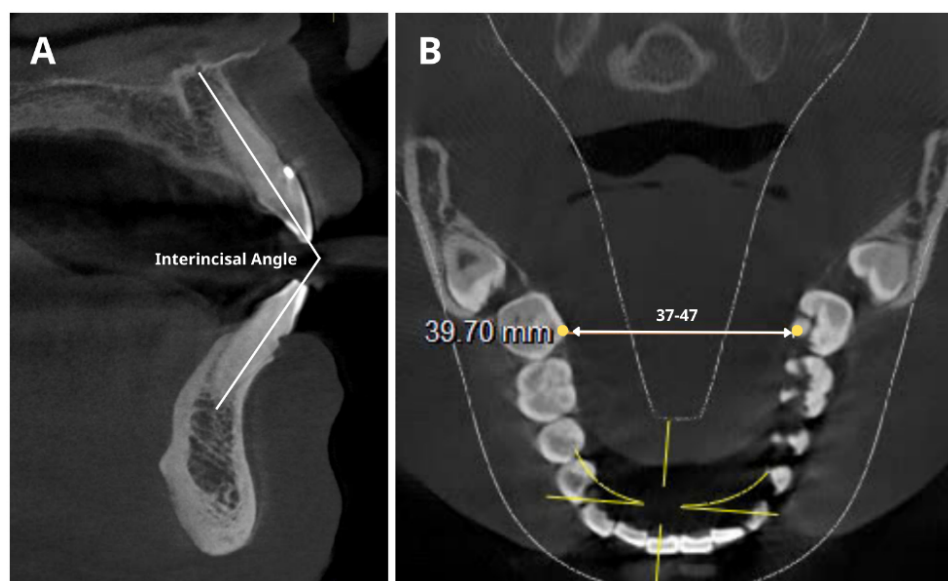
Anatomical measurements of the tongue on CBCT images: (A) cross-sectional plane and (B) axial plane.
